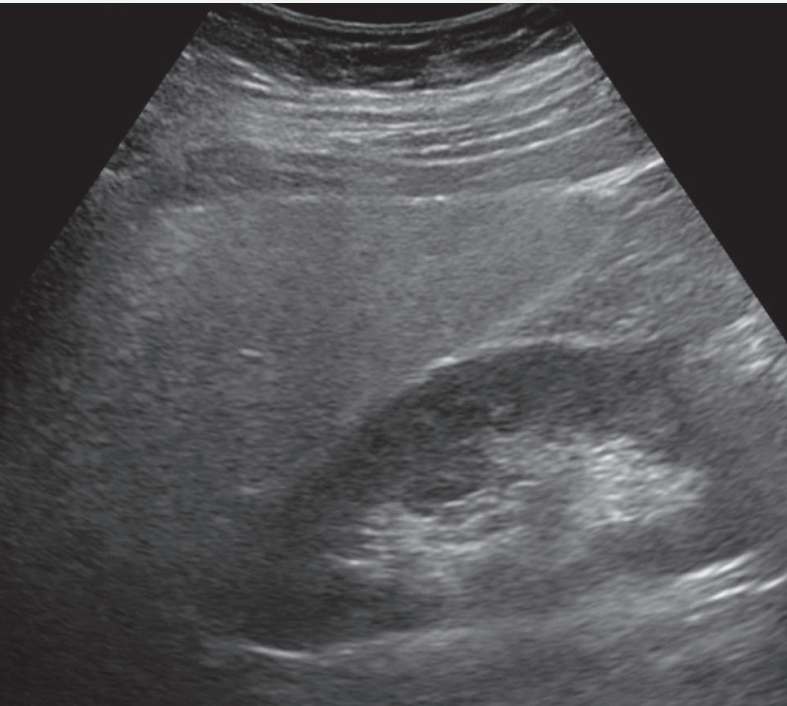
Ultrasound showing diffuse increased echogenicity of the liver
